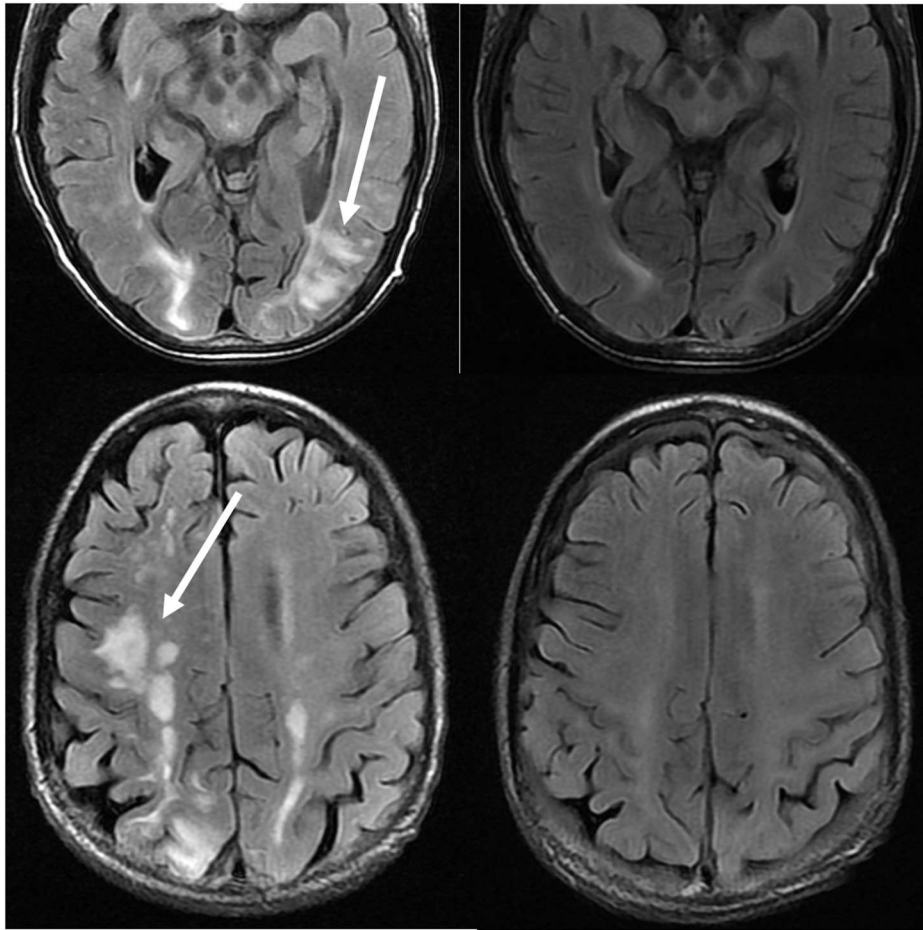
Patient with a history of primary myelofibrosis and bone marrow transplant on Tacrolimus. Axial T2-FLAIR images demonstrate the areas of signal abnormality in the parietal and occipital lobes, and right frontal lobe (left images). The Tacrolimus was stopped and the follow up images (right images) were obtained 6 weeks after the initial images.
